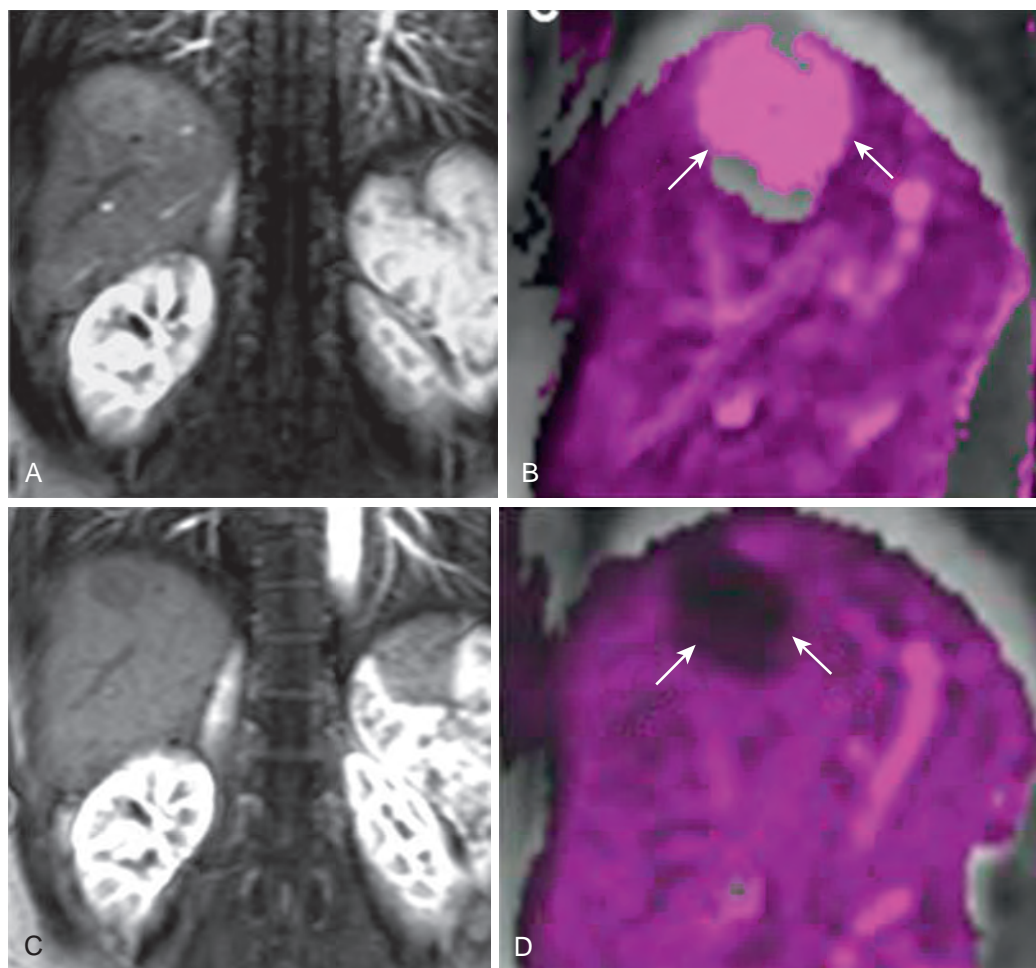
MR perfusion images before and after sunitinib therapy in a 47-year-old man with hepatocellular carcinoma. Pretreatment gadolinium-enhanced coronal T1-weighted image (A) shows the enhancing mass in the dome of the liver; the corresponding functional transfer constant (K^{trans}) map (B) was obtained after postprocessing. Two weeks after sunitinib therapy, the tumor demonstrated a reduction in enhancement (C) and a 96% drop in K^{trans} (D).
